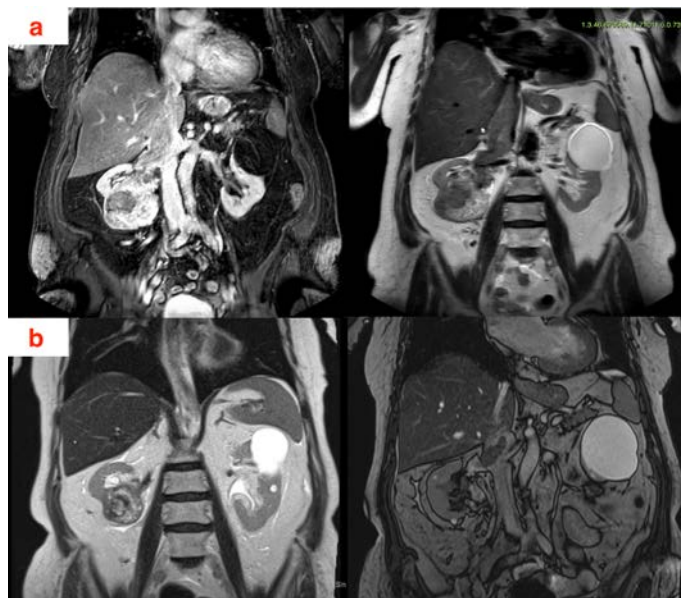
a: MRI images of case 1 before systemic treatment; b: MRI images of case 1 after systemic treatment
